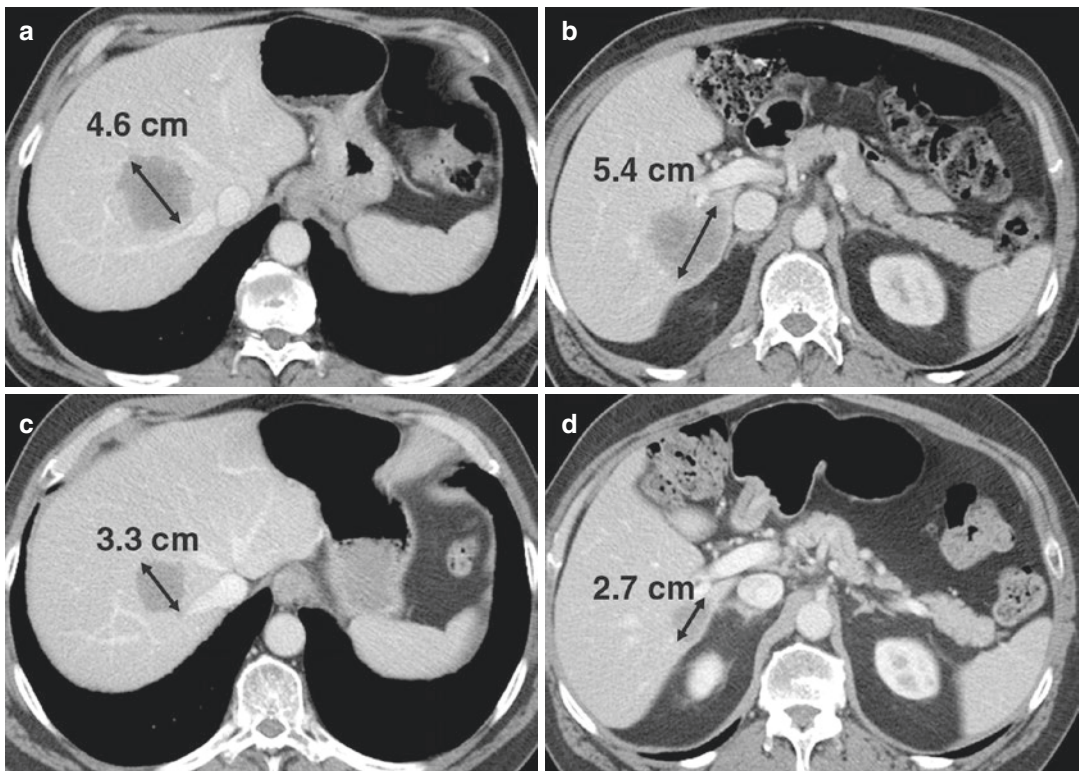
(a, b) Baseline CT scans of abdomen in 68-year-old man with colon cancer show two target lesions (arrow) in liver. Measurements according to RECIST are 4.6 cm (a) and 5.4 cm (b), totaling 10.0 cm. (c, d) Follow-up CT scans obtained after initiation of therapy show decrease in size of target lesions (arrow). RECIST measurements are
